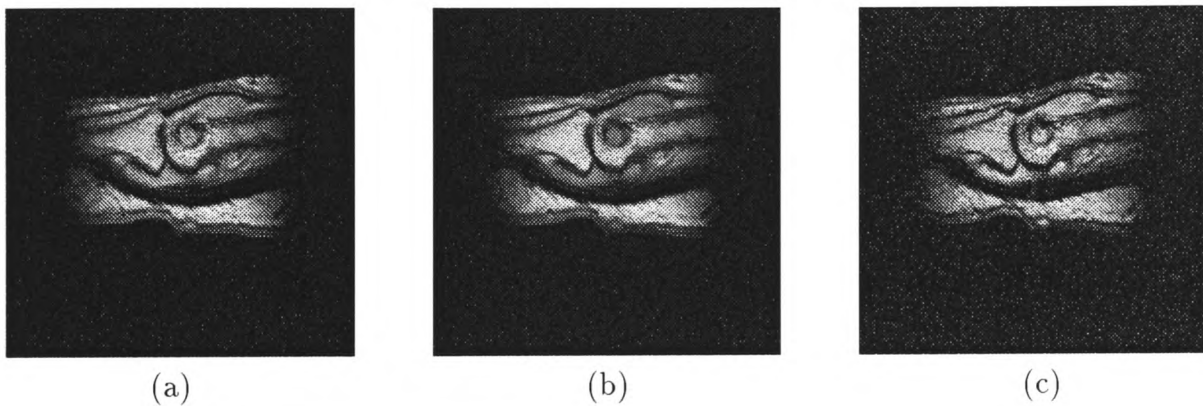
(a) PD-weighted image (b) T2-weighted image, new standardizing method (c) T1-weighted image, new standardizing method.
